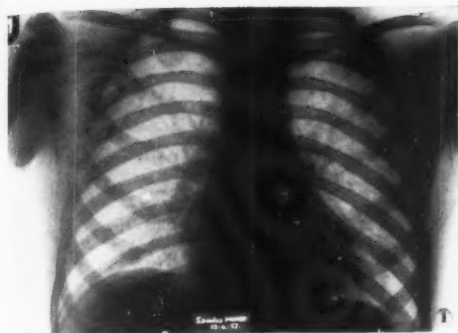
S.M. f. 6 years, Chest radiograph 6 days after Measles rash and 3 days after a secondary rise of temperature, shown later to be due to activated primary complex. Mantoux 1:1,000 positive, but not strongly, on 12th day of Measles (see chart Fig. 3).
